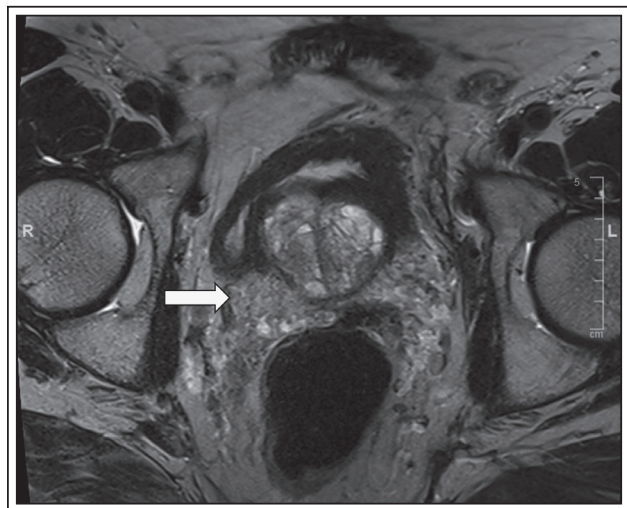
Axial T2 weighted 3T MRI image shows arrow pointing to lesion representing primary seminal vesicle epithelioid smooth muscle neoplasm of uncertain biologic potential. Posterior to lesion is fragment of right seminal vesicle; anteriorly one can see the prostate.
